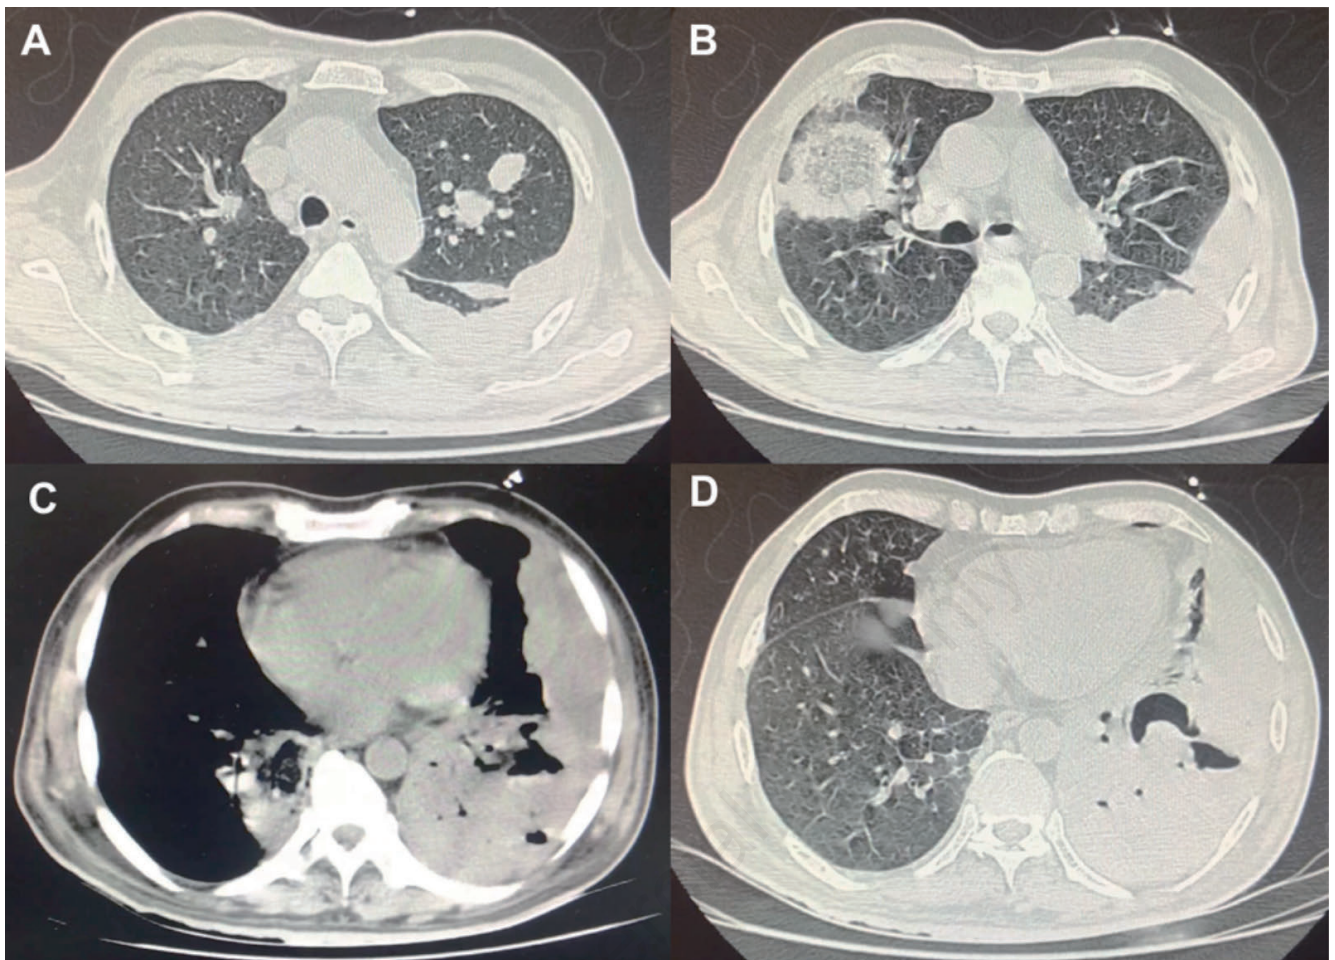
CT chest showing left upper lobe nodules, right middle lobe consolidation with reversed halo sign. Left lower lobe necrotizing consolidation with left pleural effusion.
